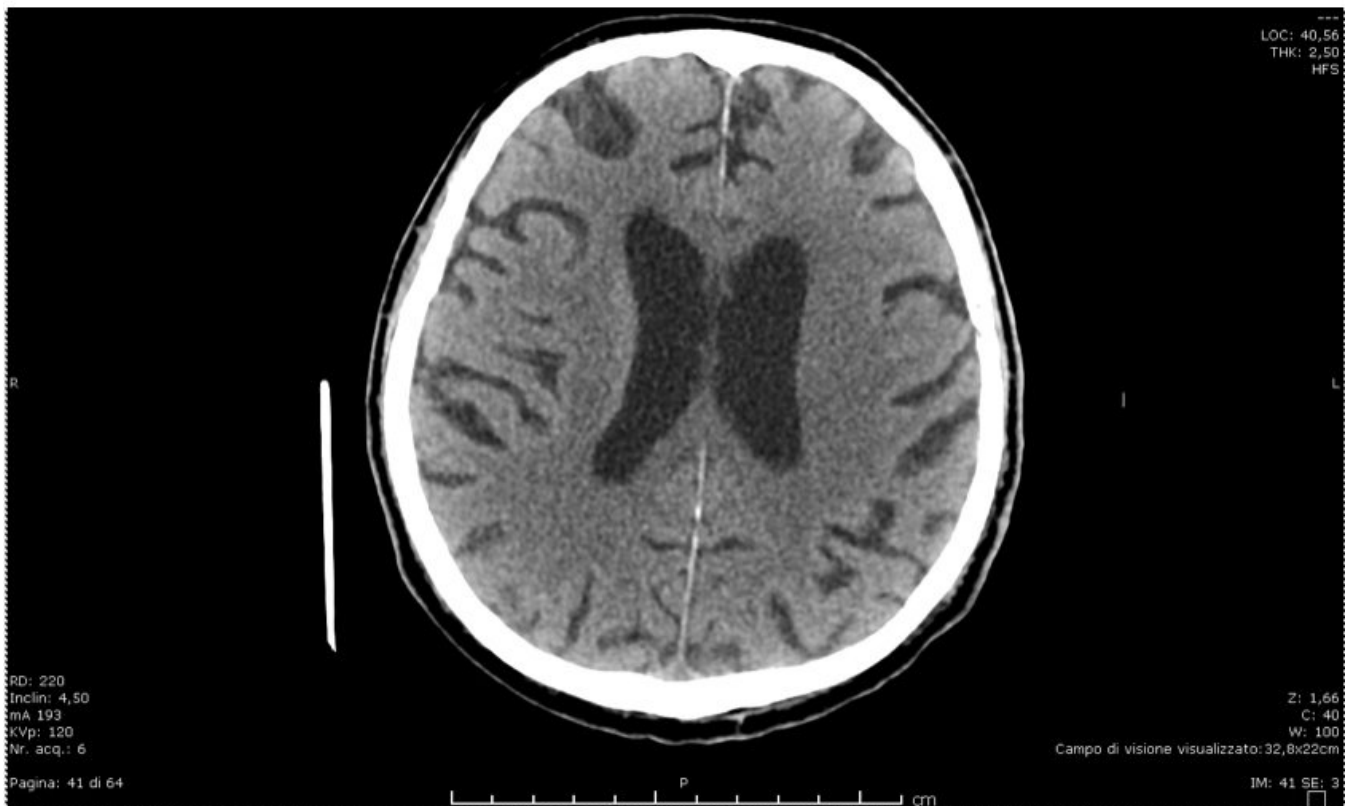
Head CT scan of the patient. There is a mild dilatation of the ventricular system without others
